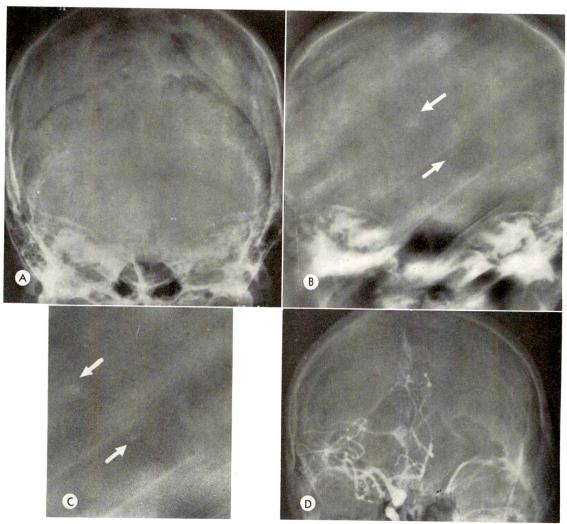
(A) The pineal gland is not visible on the anteroposterior roentgenogram. (B) A tomogram shows the pineal gland displaced to the left (lower arrow). The right choroid glomus is displaced medially (upper arrow). (C) Magnified view showing the shifted pineal gland and choroid glomus. (D) Right carotid arteriogram showing a temporal lobe mass.
